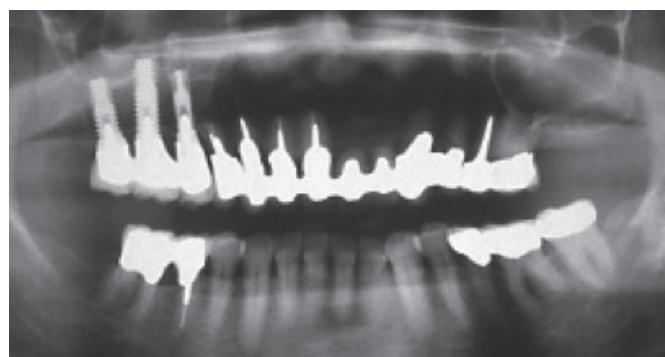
Case 6 - Final appearance and radiograph
